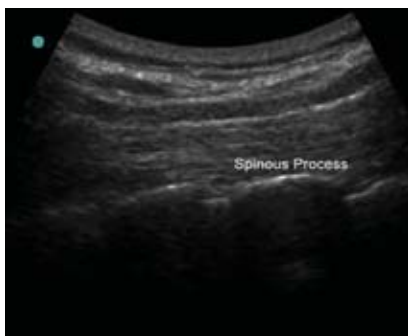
Ultrasound-guided classic approach.
